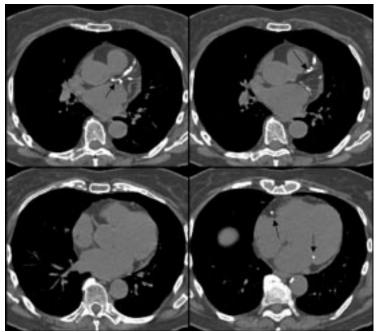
Multiple axial images of the heart from a cardiac CT examination demonstrate calcification within the coronary arteries (arrows).
